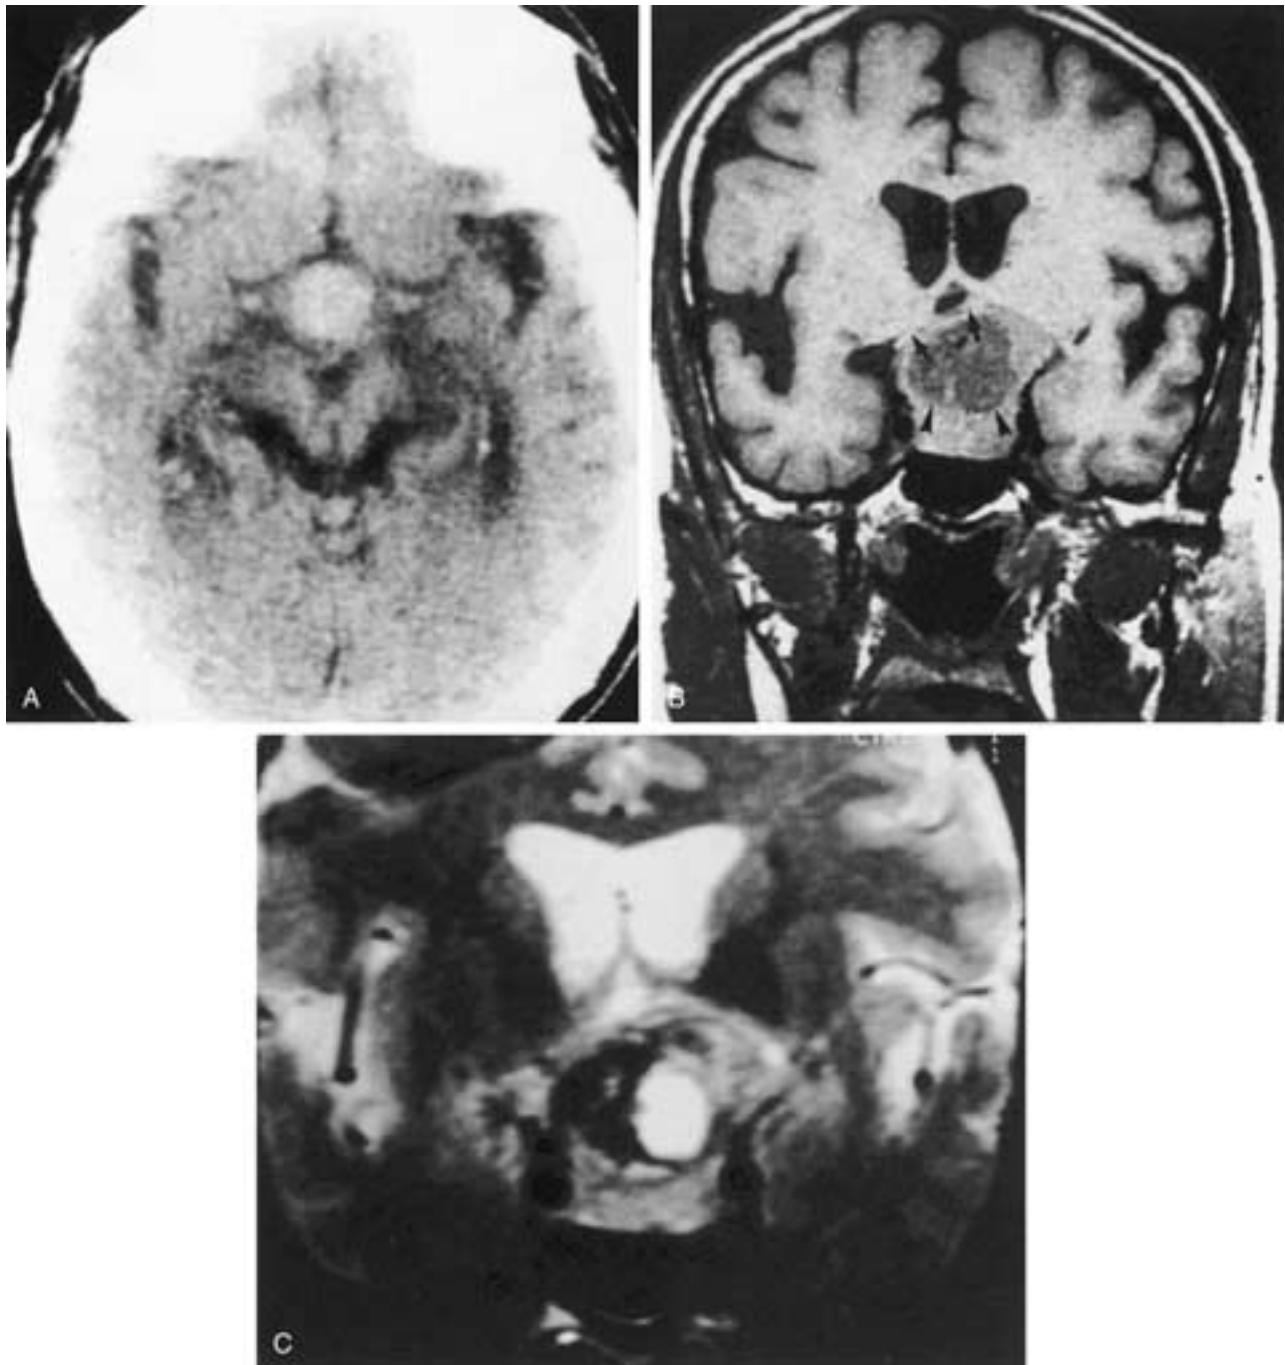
Pituitary apoplexy. A, Axial CT image without contrast medium shows a hyperdense suprasellar mass consistent with either bleeding or calcification. B, Coronal T1-weighted image shows an intrasellar and suprasellar mass extending slightly more to the left. The chiasm is displaced and compressed from below (*arrows*). The mass contains a slightly less intense zone (*arrowheads*) consistent with deoxyhemoglobin. C, Coronal T2-weighted image shows that the same area of hypointensity within the pituitary adenoma seen in B is of both high and low signal intensity. High signal intensity more to the left of the midline represents an area of cystic necrosis, whereas low signal intensity represents deoxyhemoglobin.
